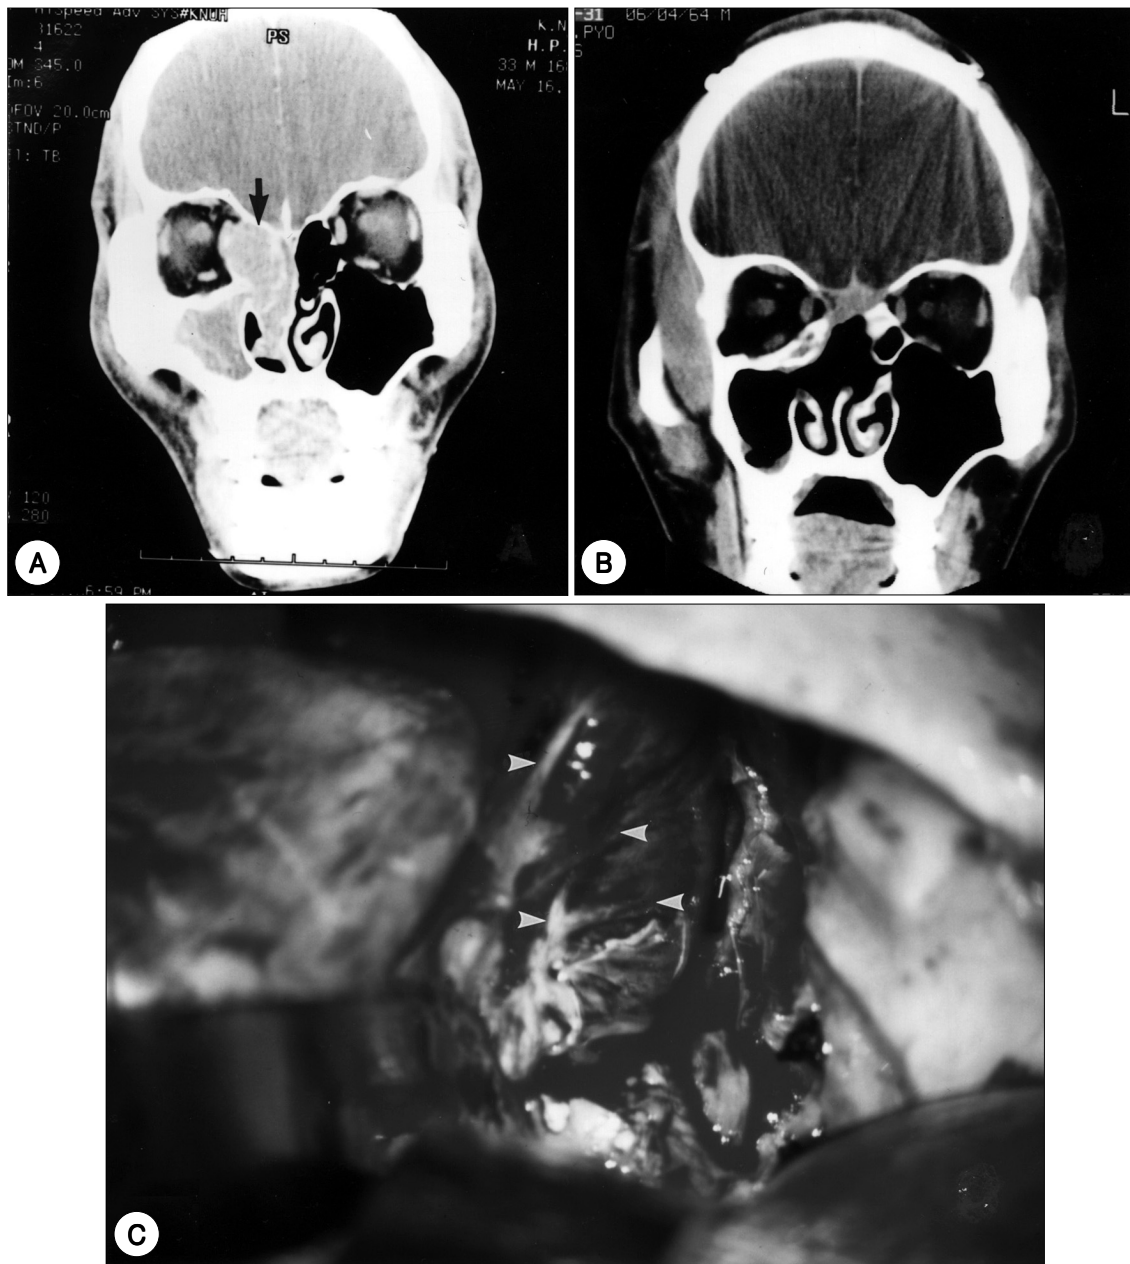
Pre- & post-treatment CT findings of case 1 treated with combined chemotherapy and radiotherapy. (A) Pre-treatment CT scan reveals faintly enhanced soft tissue density (arrow) extending into the left orbit. (B) Post-treatment CT scan shows completely disappeared tumor mass in the left nasal cavity and orbit (60 months after treatment).
